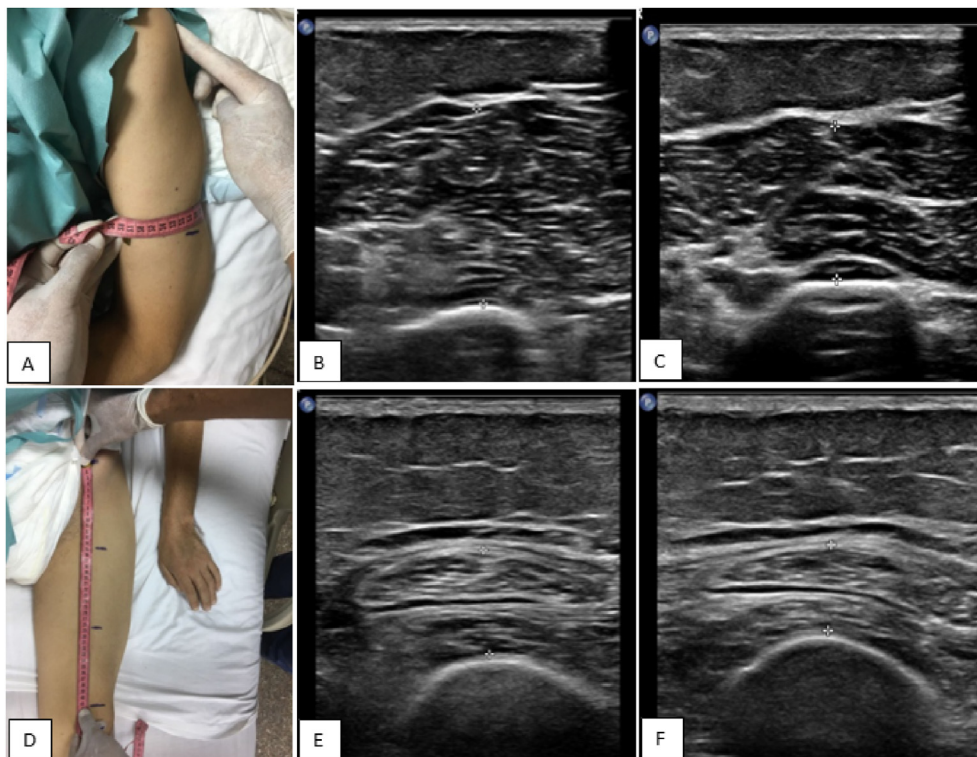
(A–F): Reference points for measuring muscle thickness and representative ultrasound images (A) reference point for anterior mid-arm (B) ultrasound image of representative flexor arm muscles without transducer compression and (C) with compression (D) reference point for lower 1/3 of the thigh (E) ultrasound image of representative quadriceps muscle without transducer compression and (F) with compression.
